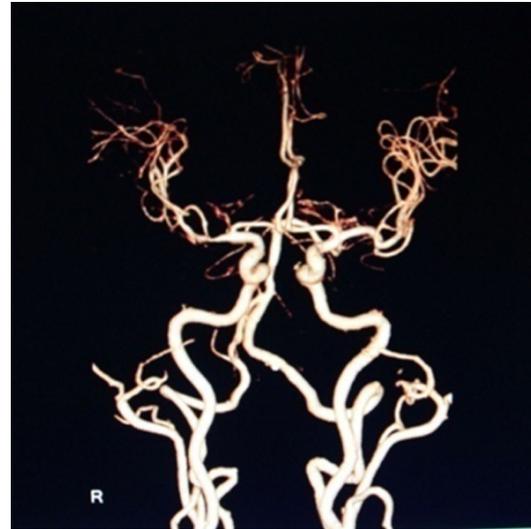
CTA performed at Jan 22th, 2015. The right MCA and ICA appeared again and arteries seemed better than four days before.
